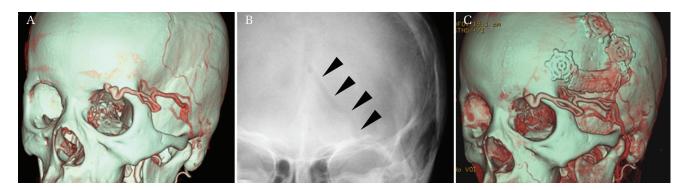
Preoperative and postoperative imaging of the patient. (A) Preoperative contrast-enhanced three-dimensional computed tomography (3DCT) reconstruction image showing an unusual subcutaneous vein under the left superior eyelid. (B) Cranial radiography, anteroposterior view, showing a straight osseous route in the frontal bone (*arrowhead*). (C) Postoperative contrast-enhanced 3DCT reconstruction image showing preservation of the venous structures of the SP.
